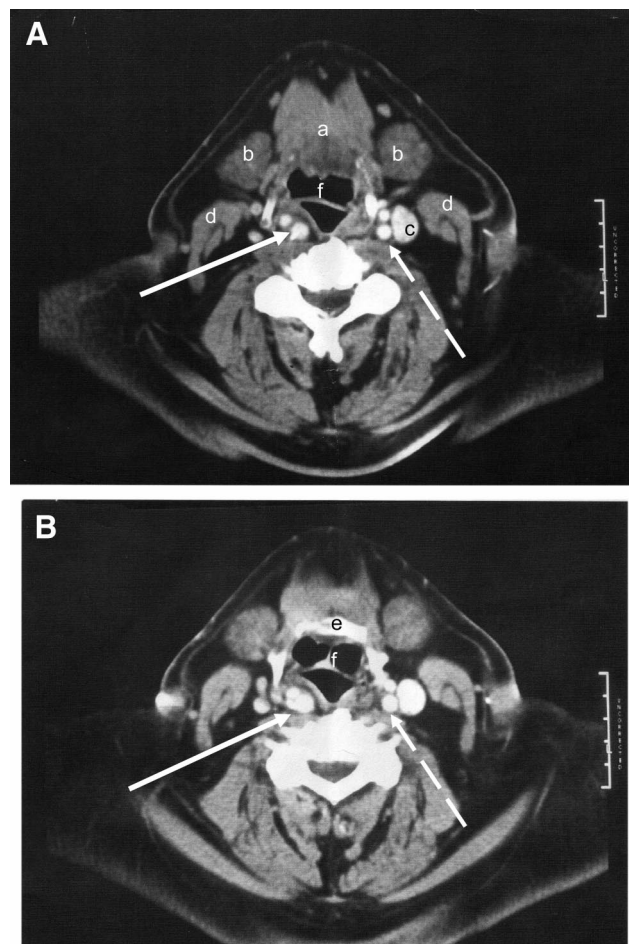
Axial computed tomography scans with contrast at the level of (A) the base of the tongue and (B) the vallecula. At the level of the base of tongue the carotid artery (white solid arrow) has bifurcated into the internal and external branches. The internal carotid artery is the larger of the two branches. At the level of the vallecula, the two branches are seen just superior to the bifurcation (white solid arrow). Additional structures seen include the tongue (a), the submandibular glands (b), the left internal jugular vein (c), the sternocleidomastoid muscles (d), the hyoid bone (e), the epiglottis (f), and the normal left carotid arteries (white dashed arrow). These images are superior to the level of the trachea and esophagus.
